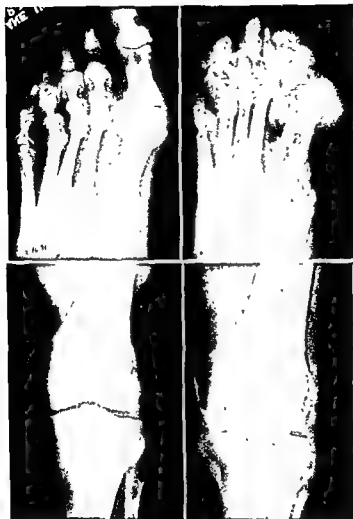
Roentgenograms showing changes during a period of twenty years in bones and joints of patient with gout A. B. Foot C. D. Knee
